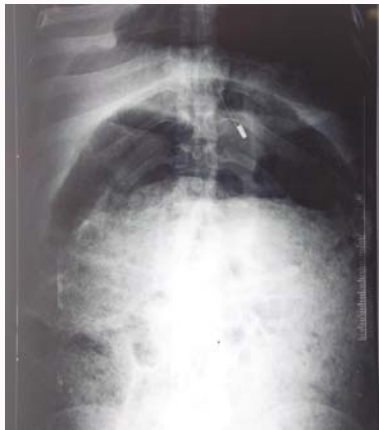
Straight X-ray Abdomen (erect) at the time of presentation.
